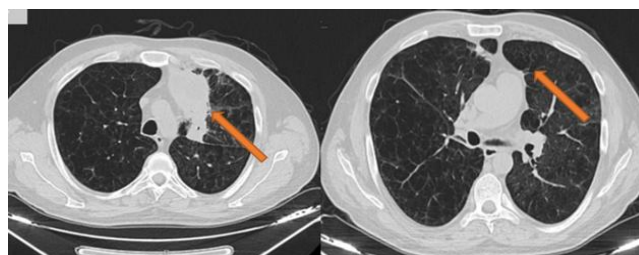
Parenchymal sections of the chest CT revealing an irregularly contoured area of consolidation measuring 3.5x6.5 cm in the left upper lobe, extending into the paramediastinal area, with a centrally cystic area measuring 4x5.5 cm in the anterior part, and a subsolid nodule measuring approximately 5 mm in diameter in the right upper lobe
